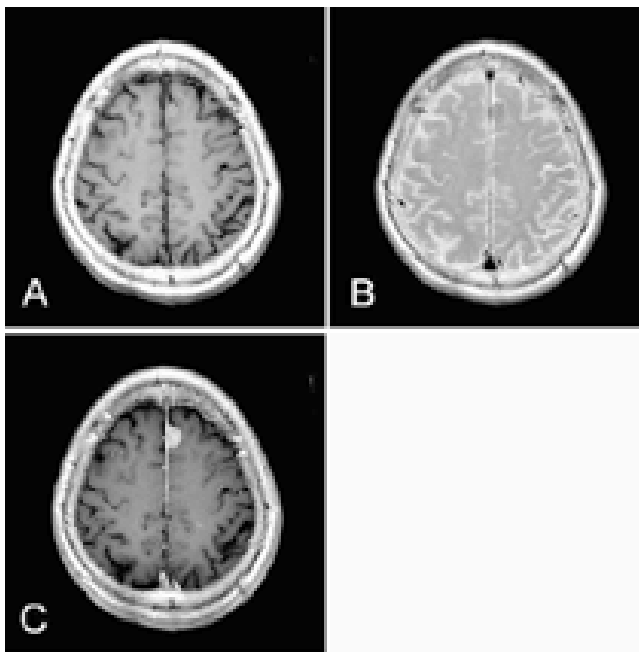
Axial MRI findings.
